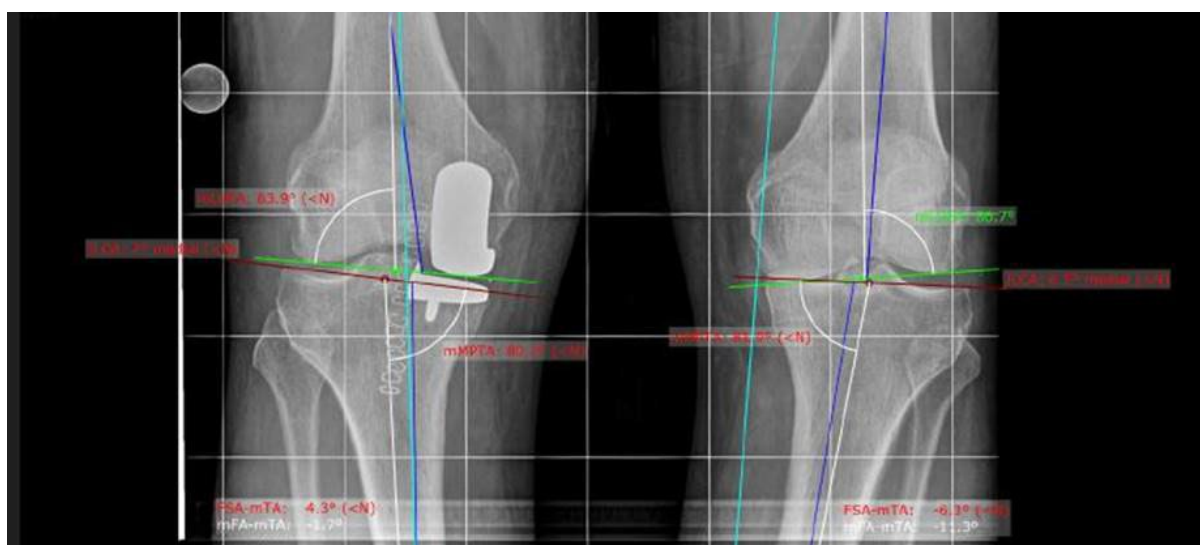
X-rays of varus coronal plane alignment in unicompartmental knee
